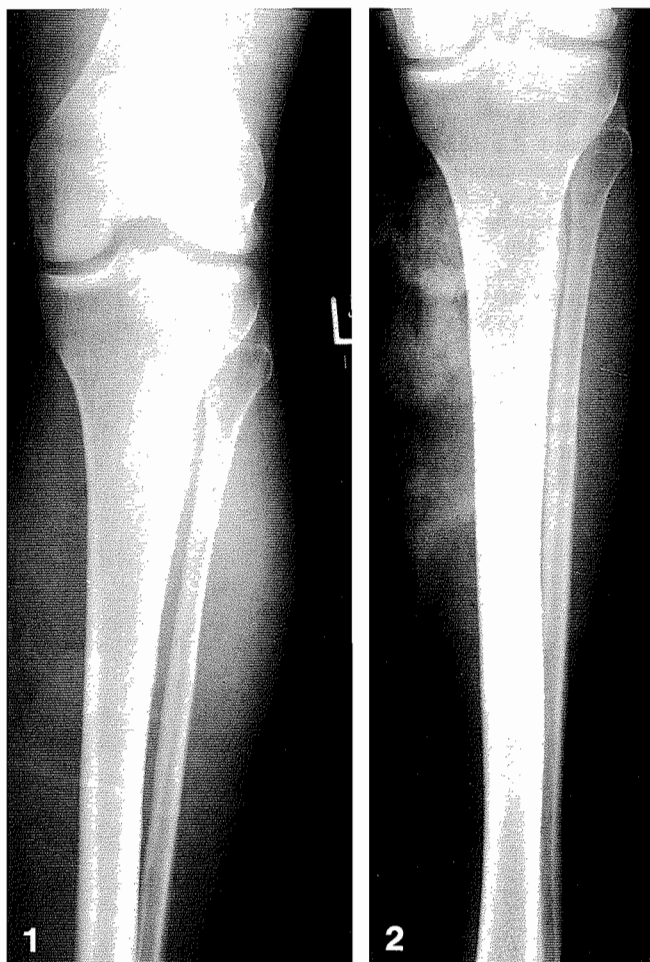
Radiograph of left calf showing early soft tissue gas formation
